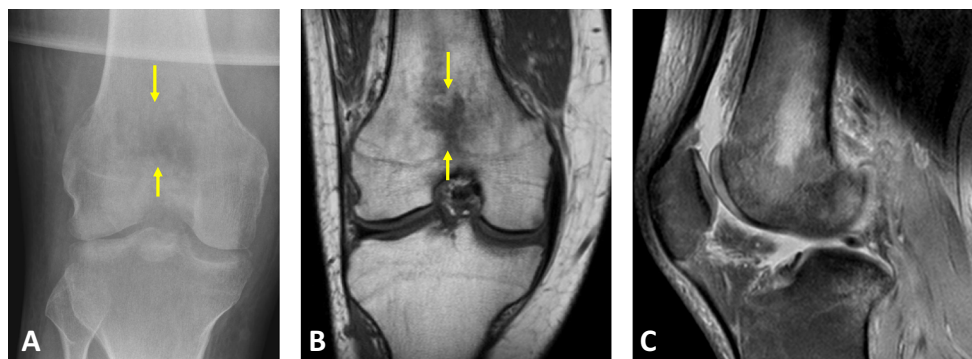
A 31-year-old male with a history of intravenous drug abuse and biopsy-proven acute hematogenous osteomyelitis. Frontal radiograph of the knee (a) demonstrates a lytic lesion of the distal femoral metaphysis (arrows) with a wide zone of transition. Coronal T1-weighted image (b)
